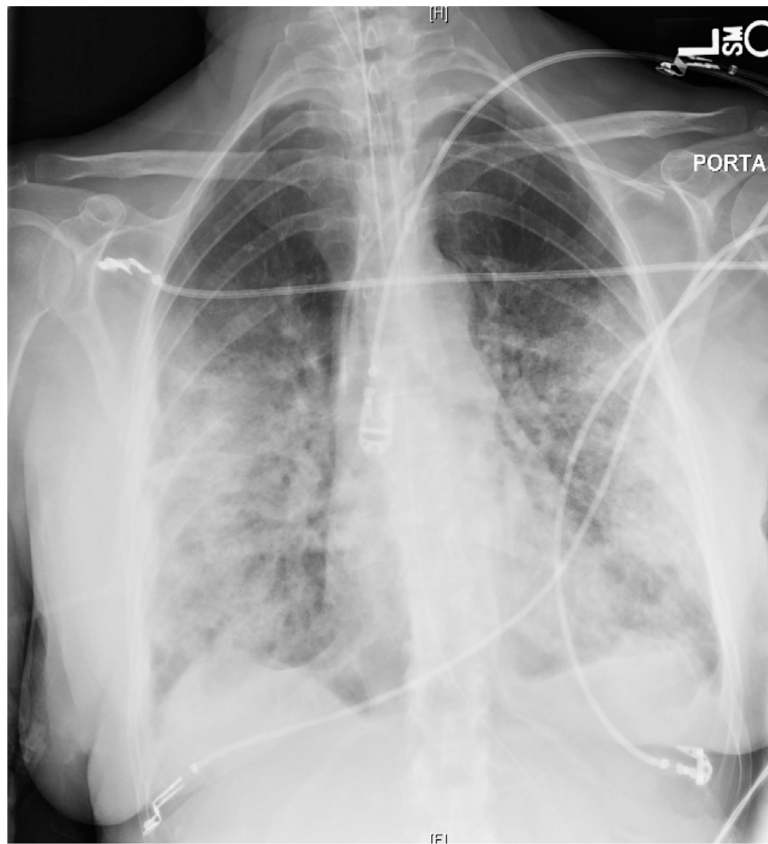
Posteroanterior chest radiograph in an elderly woman with acute hypoxemic respiratory failure secondary to respiratory syncytial virus pneumonia demonstrating dense bilateral airspace disease.
